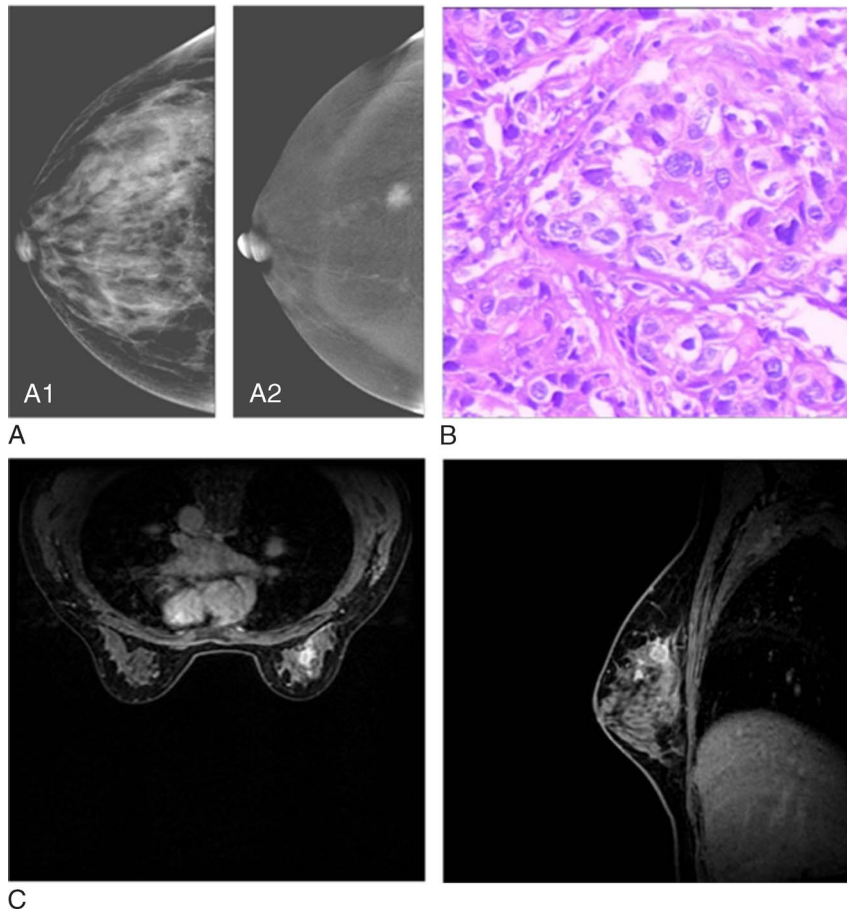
In CESM imaging, the LE (A1) image shows a diffuse high-density shadow in the right breast, with an unclear border and irregular edges; the subtraction image (A2) shows the significantly nonuniform enhancement of lesions in the outer quadrant of left breast. It is confirmed by pathological results as infiltrative ductal carcinoma (B). Magnetic resonance imaging scan shows a similar lump-like enhancement (C). Figure 1 can be viewed online in color at www.jcat.org.
